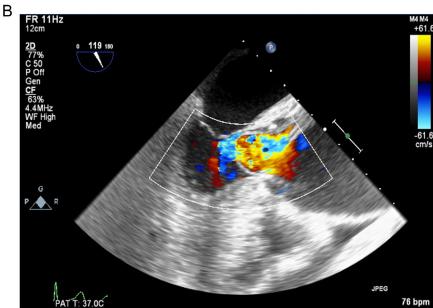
Midesophageal long-axis view of the aortic valve in diastole showing prolapse of the dissection flap through the valve (A) with color-flow Doppler (B).
